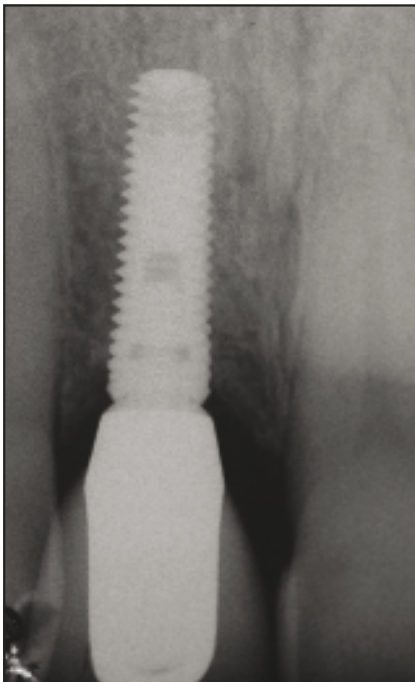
Radiographic follow-up after 12 months.
